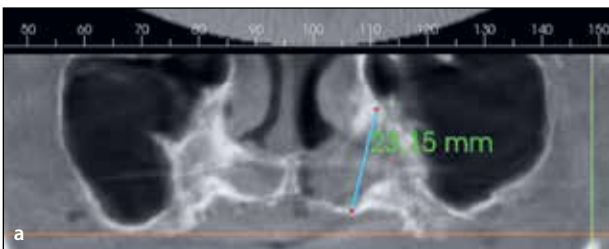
(a) 3D CBCT examination to measure the distance between the bone level and the inferior turbinate to be engaged by the nasal implant apex. (b) A craniocaudal screenshot of the 3D CBCT examination to investigate anatomical limitations; in this case, a Simmen Type I class shows high-risk damage to the nasolacrimal duct (NLD) too close to the Z point.
